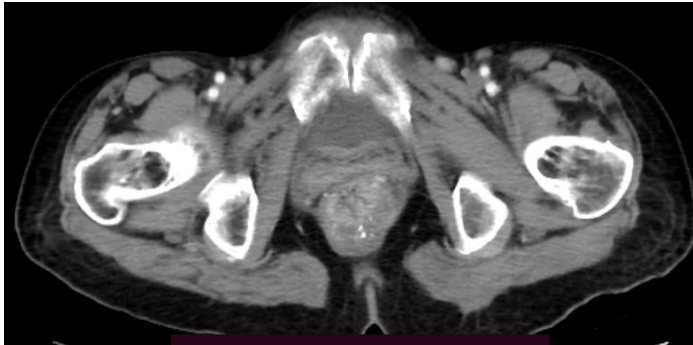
post contrast abdominopelvic CT scan of a 60yr old female patient showing an asymmetric low rectal wall thickening with internal areas of hypoattenuation and foci of calcifications seen. The mass has extension to the levator ani and external
